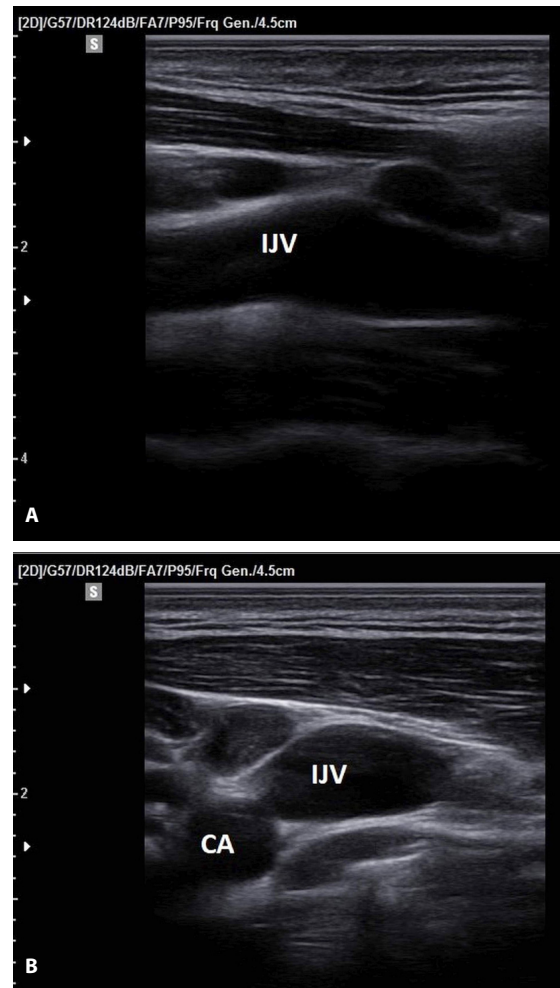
Longitudinal (A) and transverse (B) ultrasonography image of the internal jugular vein and carotid artery after treatments.
